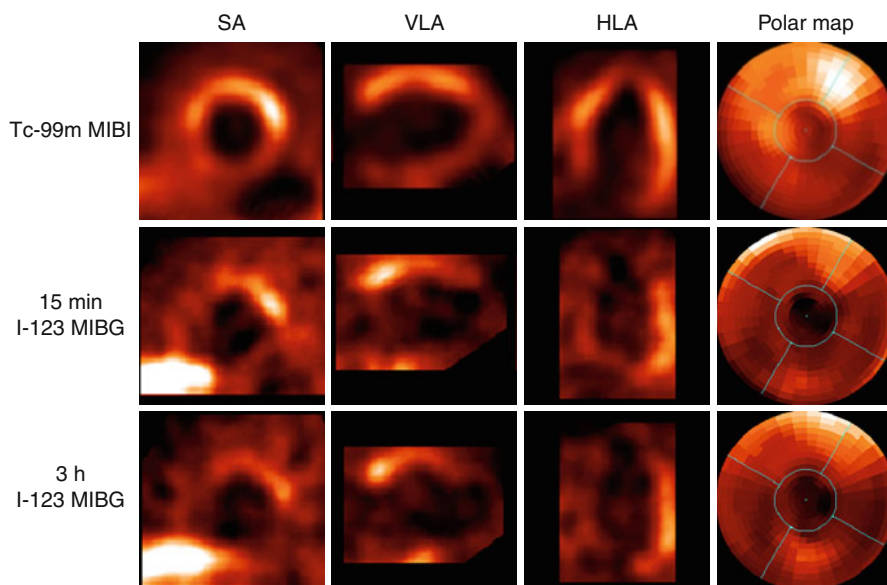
[$^{99\text{m}}\text{Tc}$]-MIBI (upper) and 15 min (*middle*) and 3 h (*lower*) [^{123}I]-MIBG SPECT images and polar maps from a patient with inferior myocardial infarction. Both 15 min and 3 h [^{123}I]-MIBG images show a larger inferior defect than [$^{99\text{m}}\text{Tc}$]-MIBI perfusion images. SA indicates short axis, VLA vertical long axis, HLA horizontal long axis
